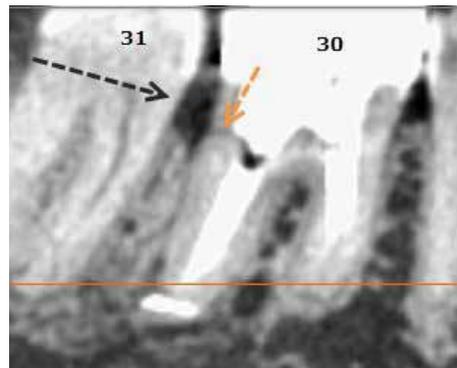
(1y follow-up cbct)
